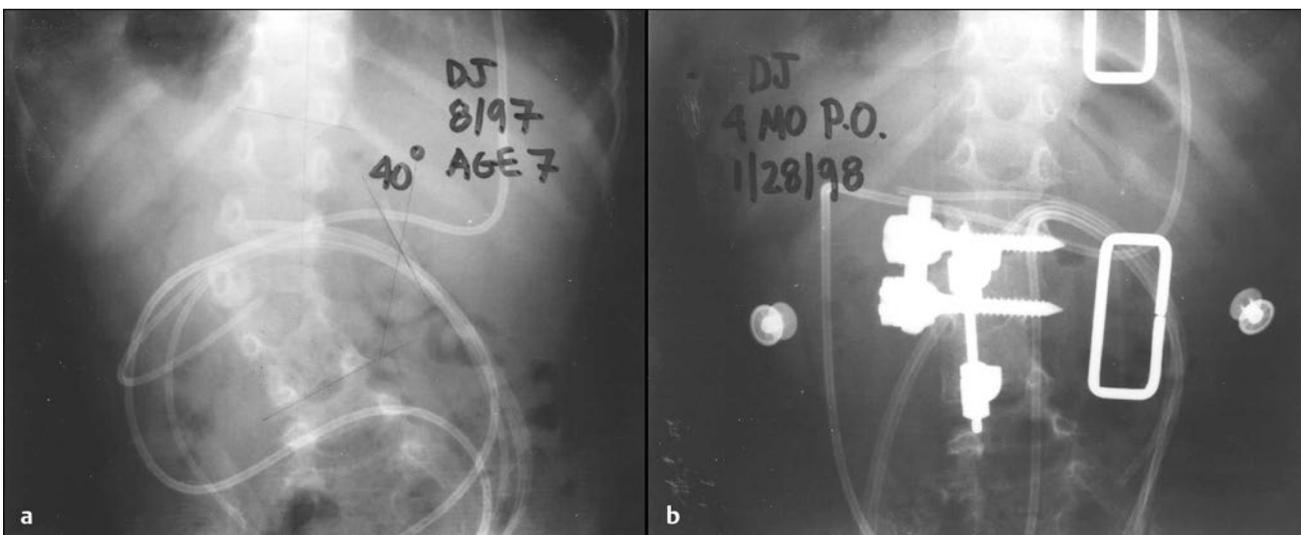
(a) Plain anteroposterior film of the thoracolumbar spine in a 7-year-old boy with an isolated hemivertebra at L3 and hydrocephalus since birth. He developed a gradual loss of coronal balance with a progressive curve. (b) Thoracolumbar radiograph 4 months after an anteroposterior hemivertebrectomy shows that his coronal balance was restored.
